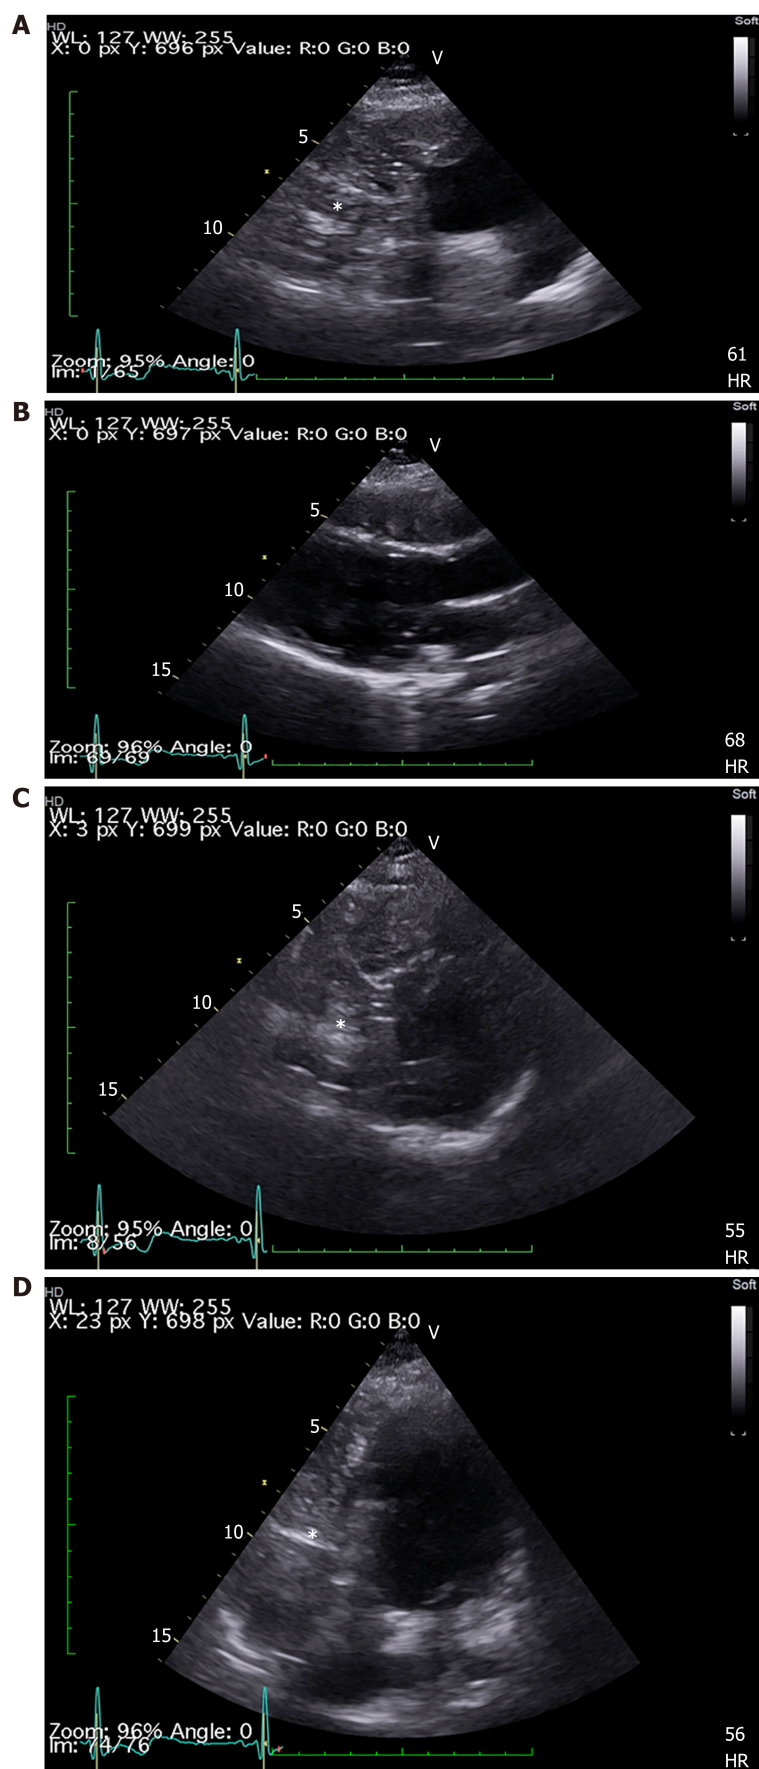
Transthoracic echocardiogram. A, C: Right ventricular mass (star) in short axis view; B: No mass in long axis view; D: Four-chamber view.
